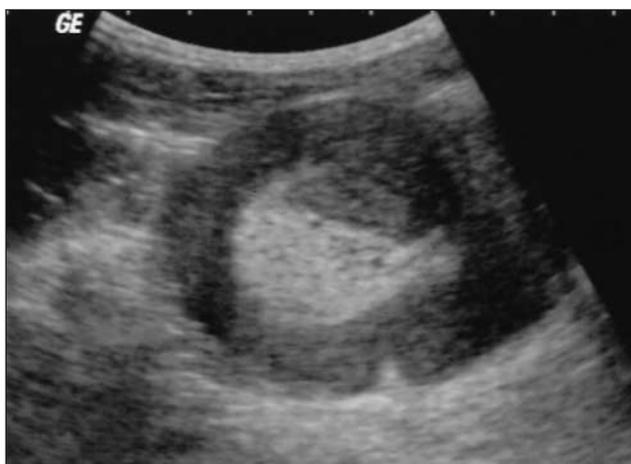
Cross-sectional ultrasound image of the same abnormality shown in Fig. 1.
